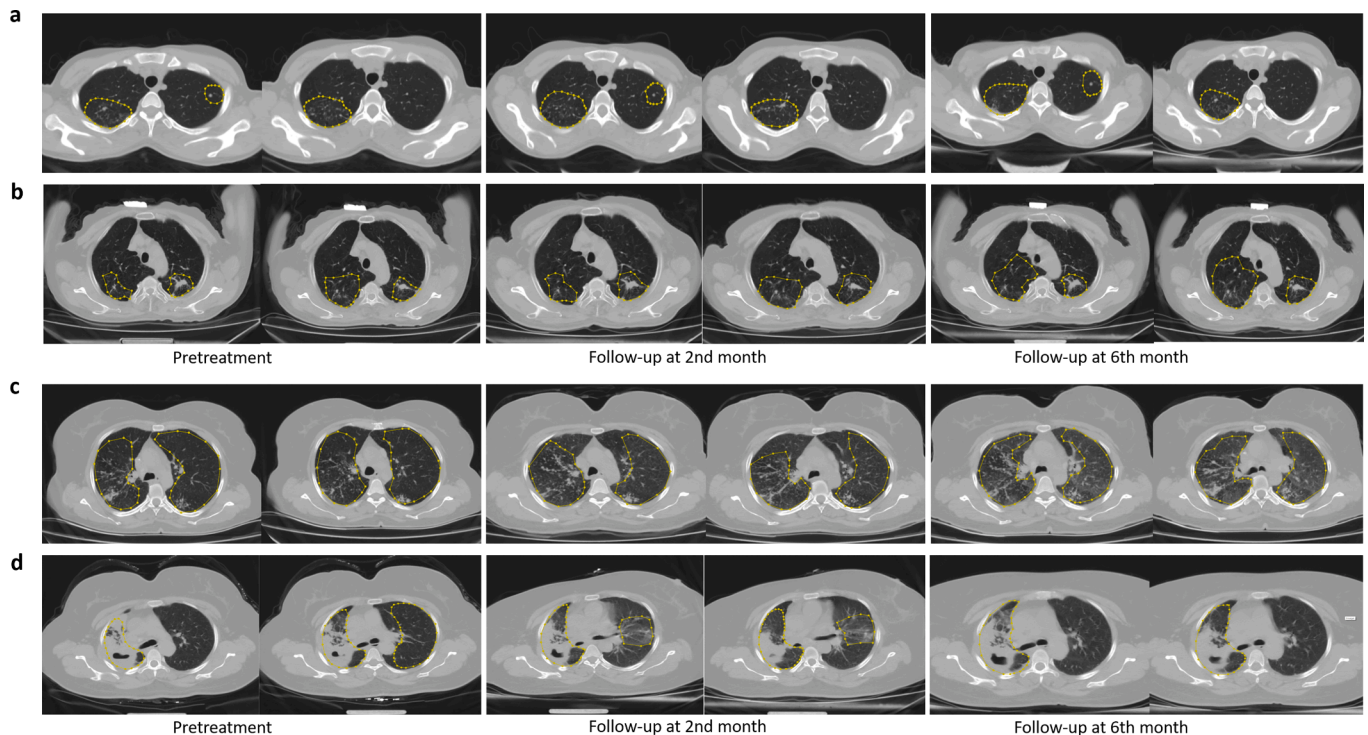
Examples of radiographic changes of success cases and DR-TB cases arranging by time. (a) Pretreatment and 2 follow-up CT scans at the 2nd and 6th month of the treatment success case with ROI information. (b) 2 follow-up CT scans 2nd and 6th month of the DR-TB case with ROI information. DR-TB, drug-resistant tuberculosis; ROI, region of interest.
